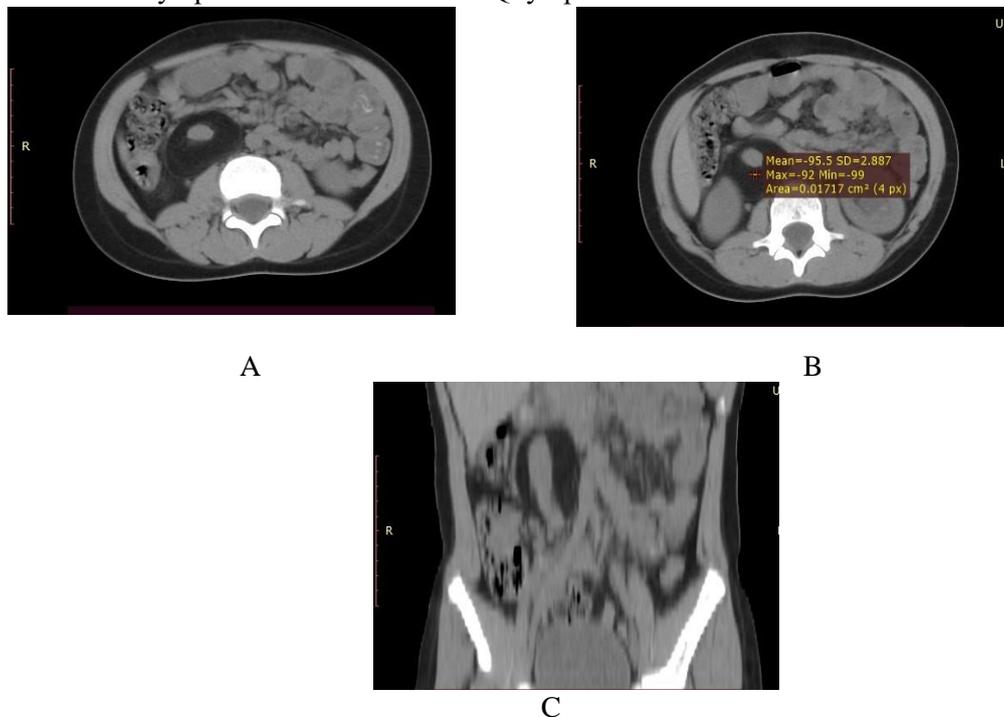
Intravascular lipoma axial CT cuts (A&B) and coronal CT cuts (C) reveals abnormal well defined hypodense lesion surround inferior vena cava by measuring the house unit density reveals -95 fatty density
